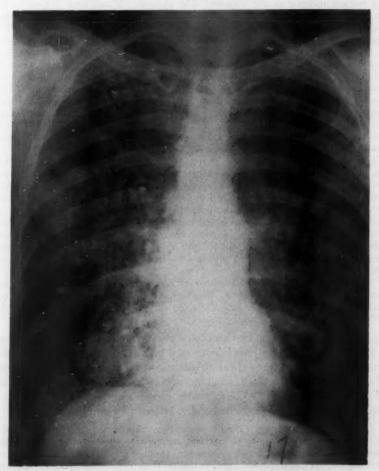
Case 3. Chest x-ray after six weeks' therapy with cortisone.
